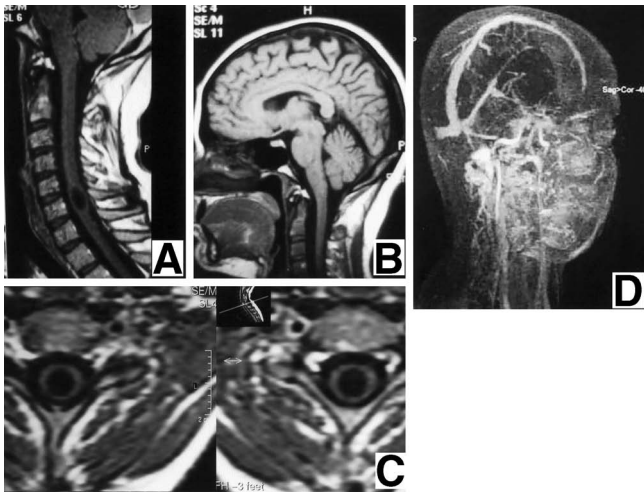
Midline sagittal T₁-weighted magnetic resonance (MR) images of the cervical spine (A) and brain (B) showing a syrinx extending from the inferior border of C-5 to the superior aspect of C-7 and normal posterior fossa without Chiari malformation. Axial T₁-weighted cervical MR images (C) showing the regular border of the syrinx cavity and no enhancement after gadolinium-diethylenetriaminepenta-acetic acid administration. MR angiogram (D) emphasizing the dominant left and narrow right transverse sinuses.
